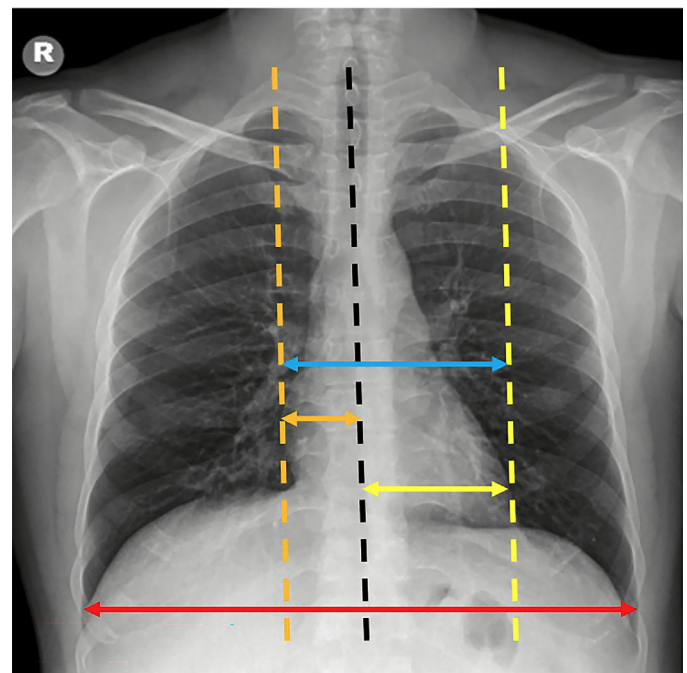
The dashed black line represents the midline in the radiograph. The orange line shows the maximum distance of the right heart border to the midline (a). The yellow line indicates the maximum distance from the left heart border to the midline (b). The red line shows the maximum transverse diameter of the chest cavity measured between the inner surfaces of the ribs (c). Cardiothoracic ratio is measured as $(a+b)/c$
